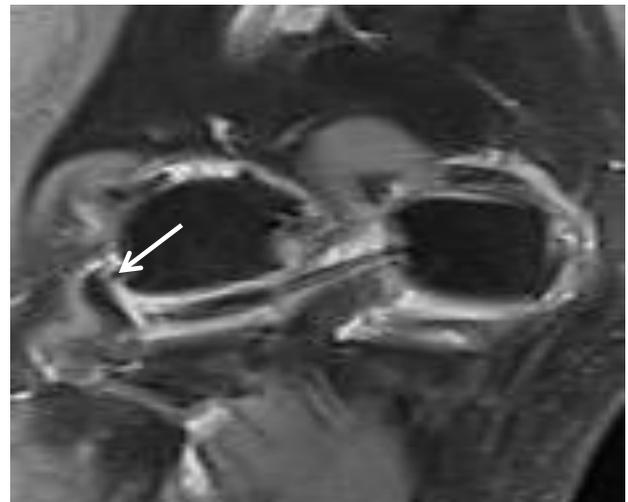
Displaced lateral meniscal tear in a 50-year-old male. Coronal T2-weighted FSE fat-suppressed image show a laterally displaced meniscal fragment (arrow).
